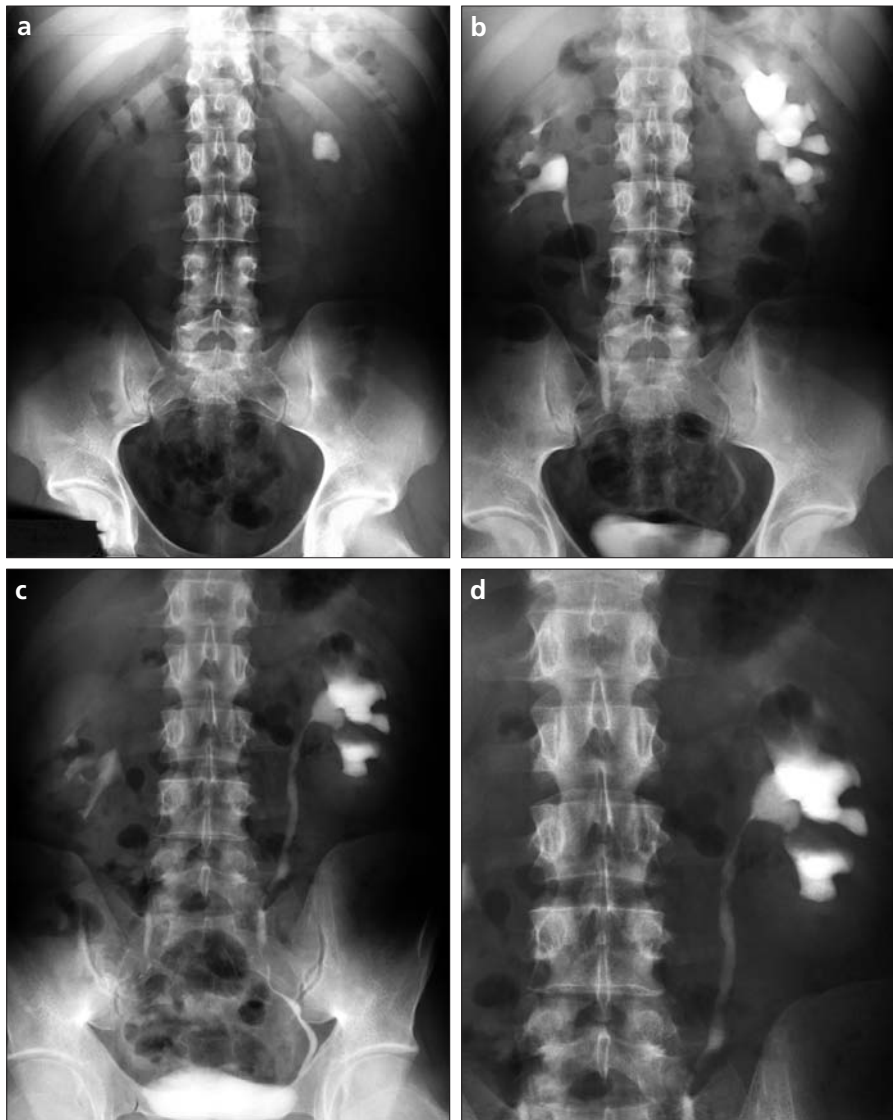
a–d. Better filling. Pre-contrast kidney-ureter-bladder (KUB) radiograph (a) shows a large radio-opacity in the left kidney region. In pyelogram phase (b–d), it is located in the left renal pelvis (b), causing moderate hydronephrosis (c). The proximal two-thirds of the left ureter is not visible in supine positioning (b), but an upright KUB radiograph (c) shows better filling of the ureter. The left ureter is completely visualized, which facilitates delineation of the narrowed uretero-pelvic junction (d), reflecting edema or stricture.
